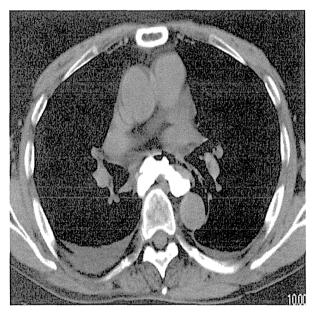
Chest computed tomography with oral water-soluble contrast material revealed the extravasation of contrast agent into the mediastinum and bilateral pleural effusions. These findings are consistent with a ruptured esophagus
